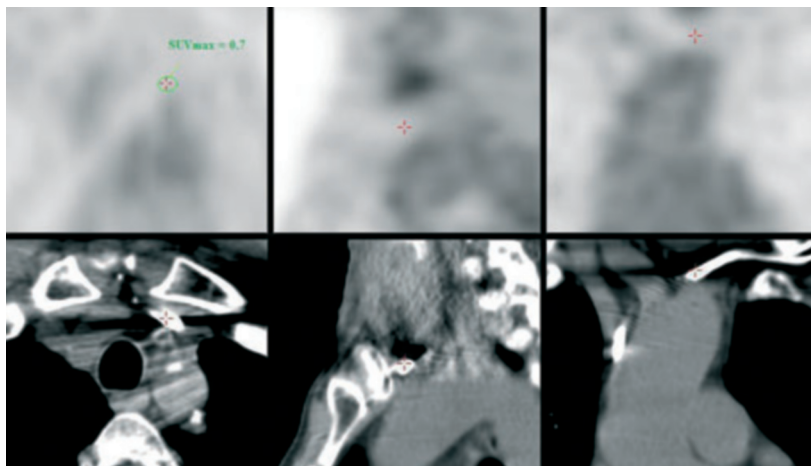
Lead infection. Top: transverse (left), sagittal (medium) and coronal (right) slices displaying a focal hot spot on a lead (circle), indicating lead infection. Bottom: corresponding computed tomography slices.
